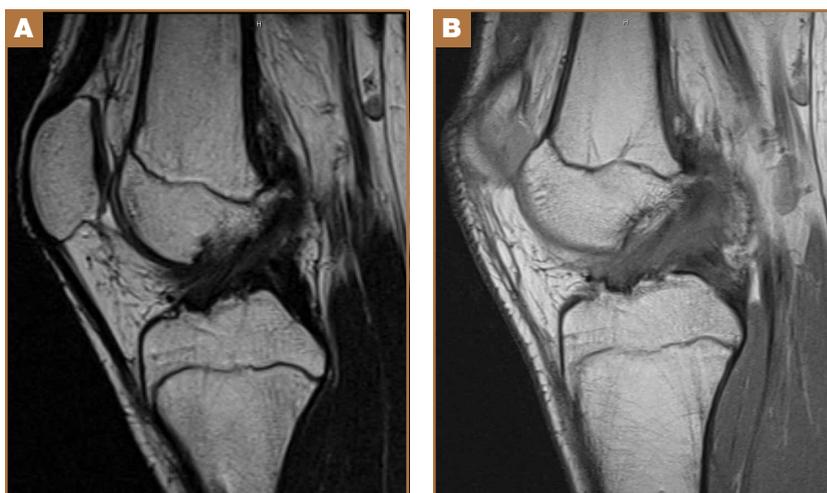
Sagittal T1-weighted magnetic resonance imaging showing (A) interval healing of the previous anterior cruciate ligament tear with (B) intact insertions.
